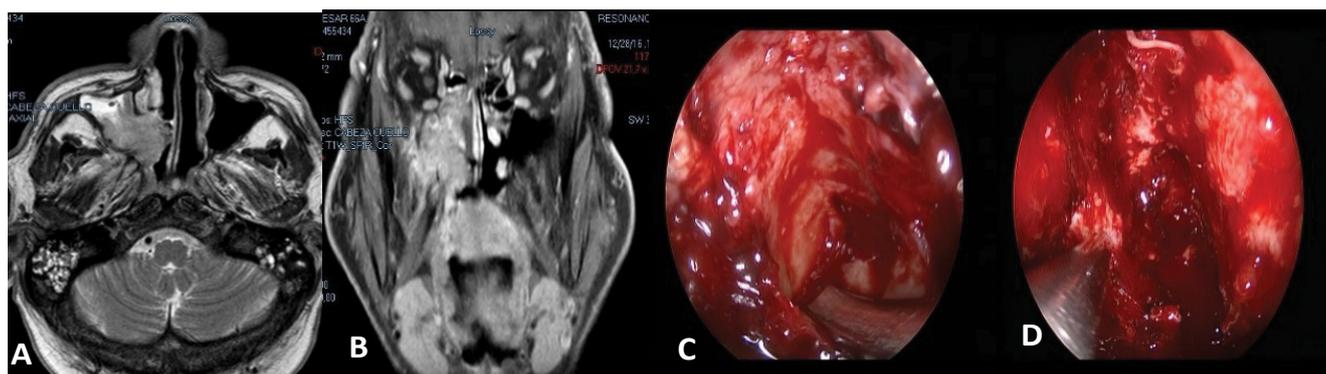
(A and B) MRI: A tumor is observed that compromises the posterior wall of the maxillary sinus with extension to the pterygomaxillary fossa and bone invasion of the ethmoid roof; (C, D) Endonasal view with endoscopes at the end of surgery. He did postoperative CT + RT.
